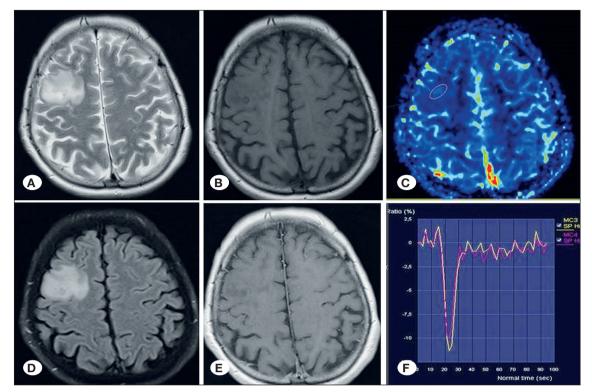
A 48-year-old male patient. T2-weighted (A), FLAIR (B), T1-weighted (C), and contrast-enhanced T1-weighted (D) images reveal a tumor in the right frontal lobe. The CBV map (E) and time-to-signal intensity curve (F) are shown. The rCBVmax is 1.96 and the PSR¹ is 0.98. The pathological diagnosis was grade 2 astrocytoma with an IDH mutation.
